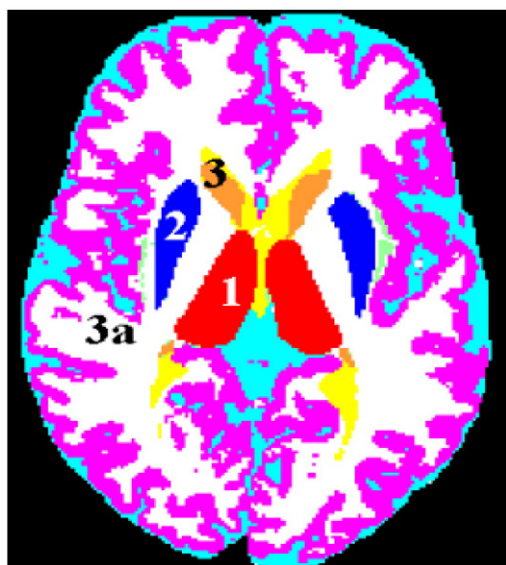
Axial MRI tissue segmented image. This figure displays manually segmented areas of the thalamus (1); putamen (2); head of caudate (3); tail of caudate (3a).
